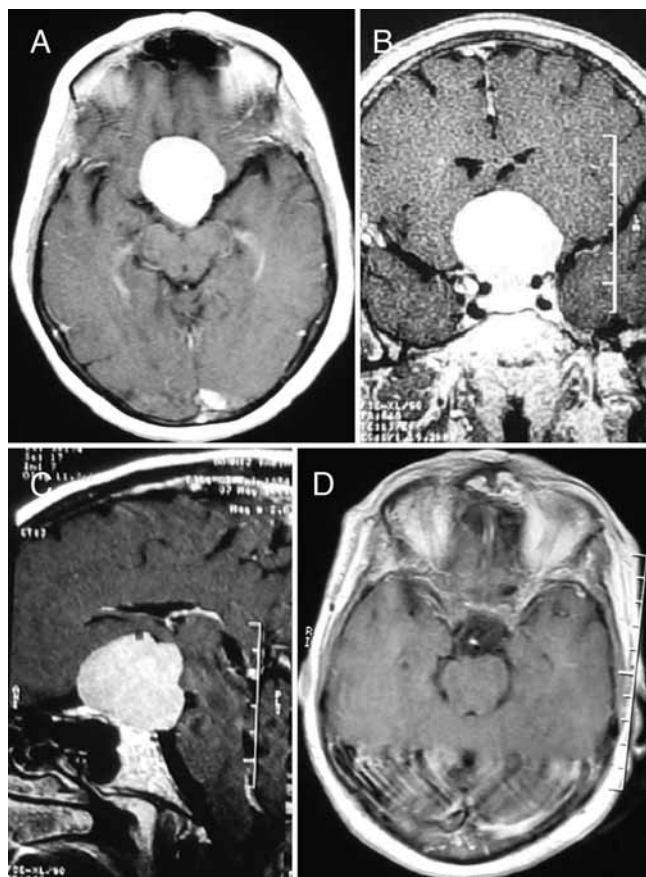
Case 2. A–C: Preoperative T1-weighted, postcontrast axial (A), coronal (B), and sagittal (C) MR images showing a very large tuberculum sellae meningioma. D: Postoperative T1-weighted, post-contrast axial MR image demonstrating gross-total tumor resection at the 6-month follow-up.
